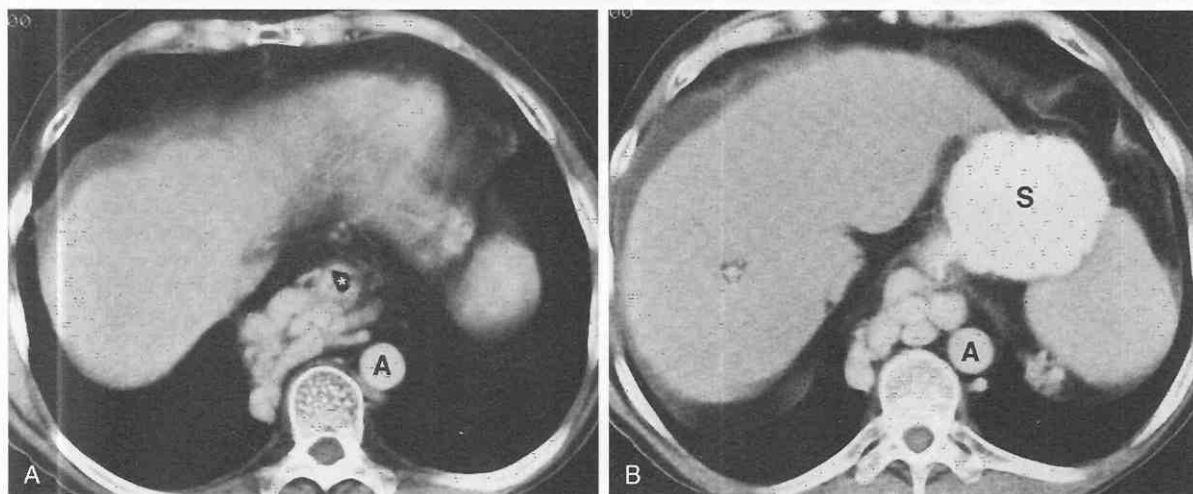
Esophageal varices. A and B, Contrast-enhanced CT shows multiple tubular contrast-enhancing structures surrounding the distal esophagus (asterisk on A), compatible with esophageal varices. Note moderate ascites. A, aorta; S, stomach.
